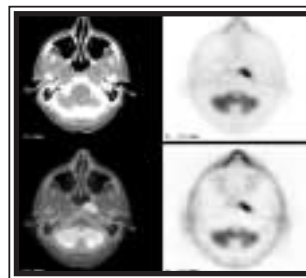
Integrated PET/CT of 60-year-old nonsmoker with a left neck mass of two months' duration. CT scan confirmed left neck adenopathy but revealed no primary tumor. Based on these findings, treatment including surgical excision of neck mass was initially proposed elsewhere. PET/CT reveals primary tumor in nasopharynx, which was treated successfully with radiotherapy alone.
